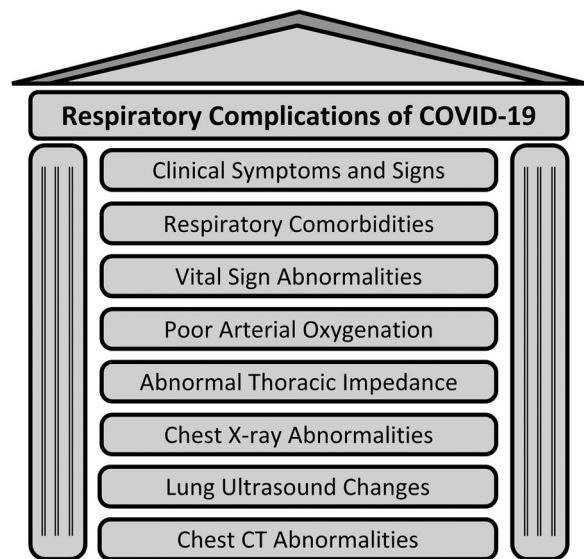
Biomarker assessment of respiratory complications related to coronavirus disease 19 (COVID-19). CT, computed tomography.
